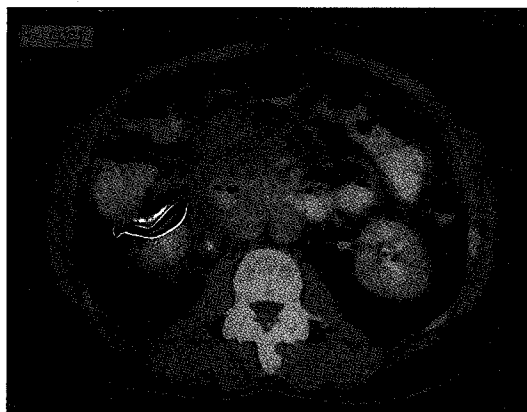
CT scan shows pancreatic swelling, peripancreatic fluid and inflammatory stranding involving ureter resulting in peri-ureteric wall thickening.
